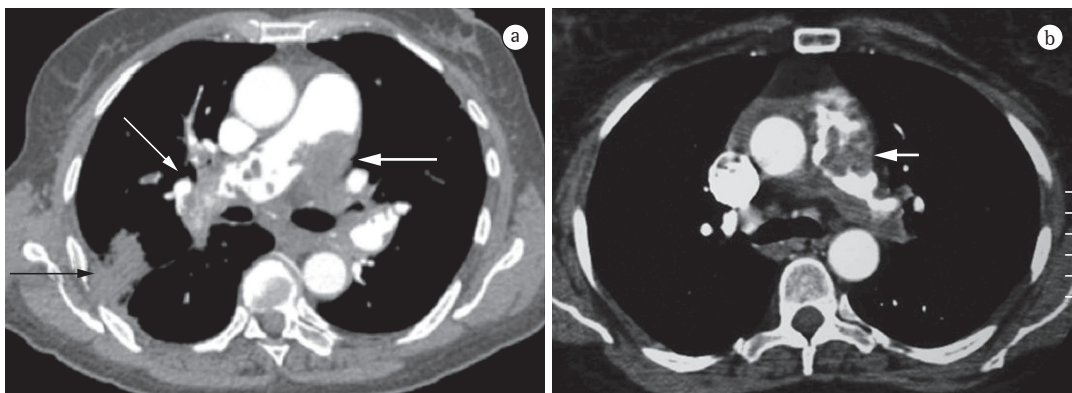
In a, chest CT angiography of Case 1 revealing dilatation of the pulmonary artery and irregular filling defects, notably in the main pulmonary artery (thick white arrow) and in the right branch of the pulmonary artery (thin white arrow), as well as peripheral pulmonary consolidations (black arrow). In b, chest CT angiography of Case 2 showing irregular filling defects in the main pulmonary artery (white arrow).
